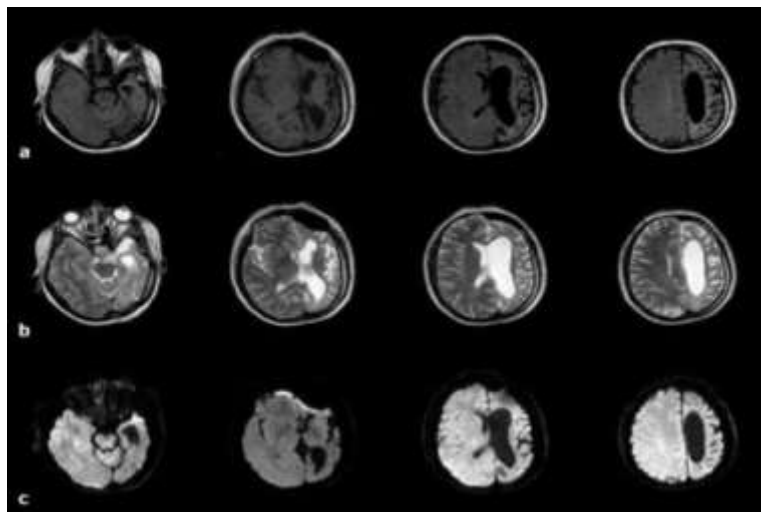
Axial FLAIR (a) T2 weighted images (b) and diffusion weighted images (c) confirm CT findings
